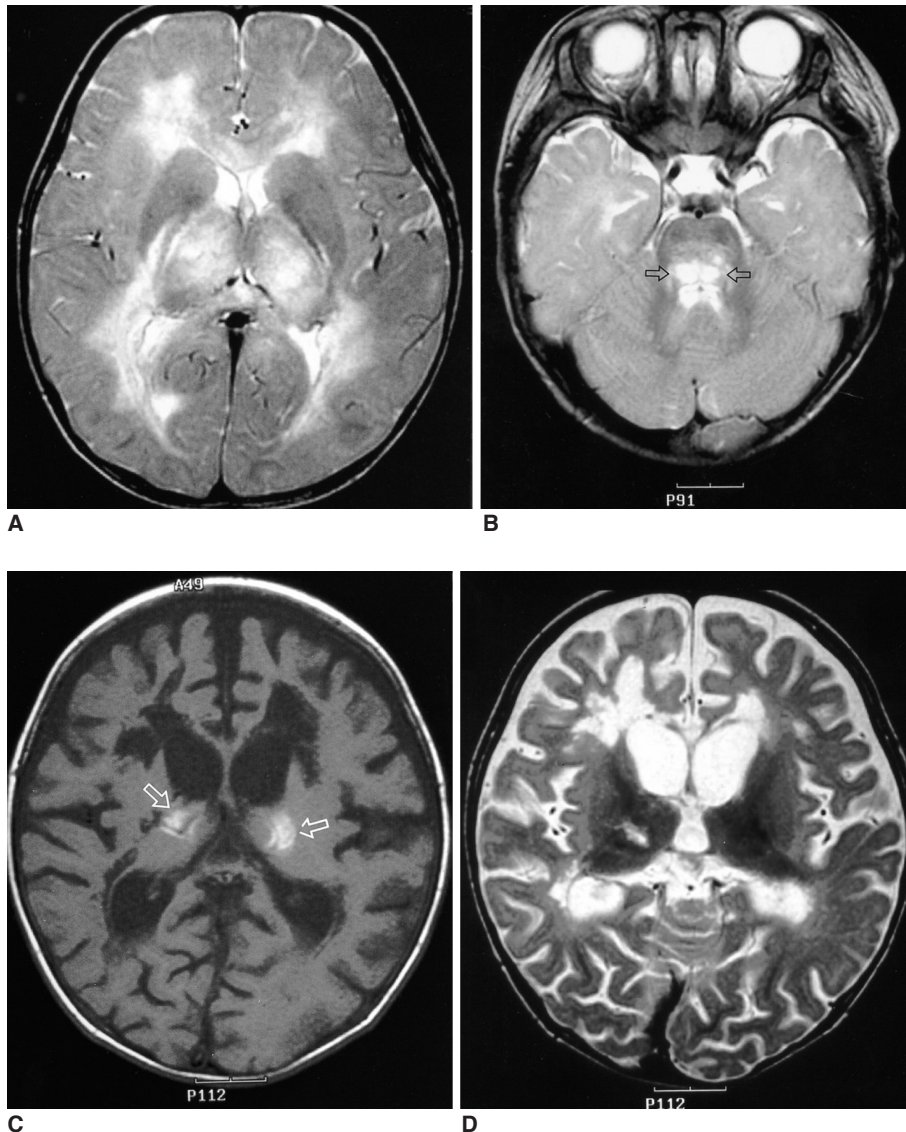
MRIs of a 10-month-old girl (patient 4) who was left with severe sequelae. A, B. Initial MR images obtained on the day following the hospital admission. T2-weighted axial images (A, B) show increased signal intensity in the thalami, the posterior internal capsule, putamen, periventricular white matter and the tegmen of the pons (arrows). C, D. Follow-up MR images obtained after one month of initial study. The T1-weighted image (C) shows shrunken thalami, localized low signal intensity that was similar to the cerebrospinal fluid in the periventricular white matter, and generalized atrophy of the cerebral hemispheres. The patches of bright signal intensity in the bilateral thalami (open arrows) suggest a subacute stage of hemorrhage. The localized bright signal intensity in the periventricular white matter and in the right thalamus on T2 weighted images (D) suggest the cystic evolution.
